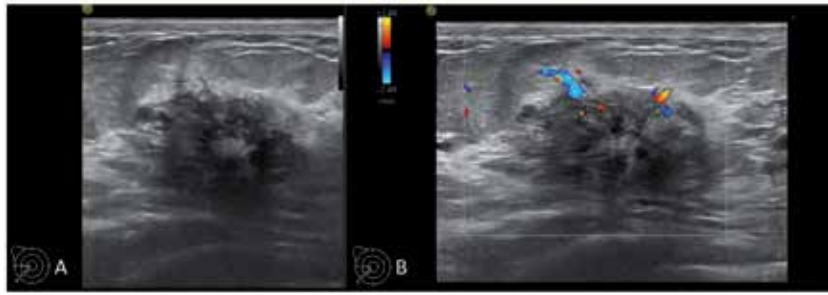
ILC presented as a heterogeneous mass, with small cystic areas included and ill-defined margins (A), vascularized on color Doppler (B). Note the mass orientation, parallel to the surface, with a “wider than tall” appearance.
